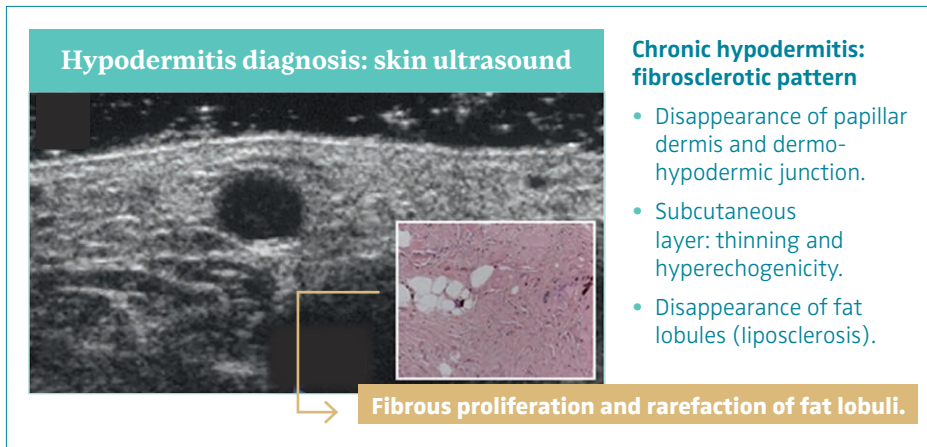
Skin ultrasound of chronic hypodermitis: fibrosclerotic pattern. Ultrasonography of skin changes in legs with chronic venous disease.
